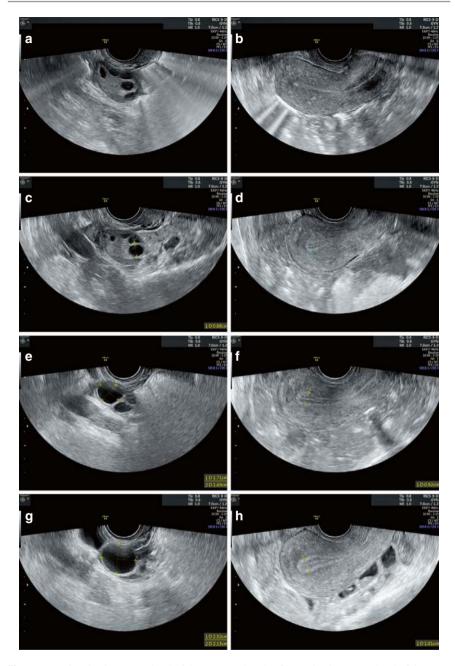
(a) Ovarian image on day 4 of the menstrual cycle. (b) Uterine image on day 4 of the menstrual cycle. (c) Measurement of the dominant follicle on day 8 of the menstrual cycle. (d) Uterus and endometrium on day 8 of the menstrual cycle. (e) Measurement of the dominant follicle on day 12 of the menstrual cycle. (f) Measurement of endometrial thickness on day 12 of the menstrual cycle. (g) Measurement of the dominant follicle on day 15 of the menstrual cycle. (h) Measurement of endometrial thickness on day 15 of the menstrual cycle. (i) Ultrasound image after ovulation on day 16 of the menstrual cycle. (j) Uterus and endometrium on day 16 of the menstrual cycle
